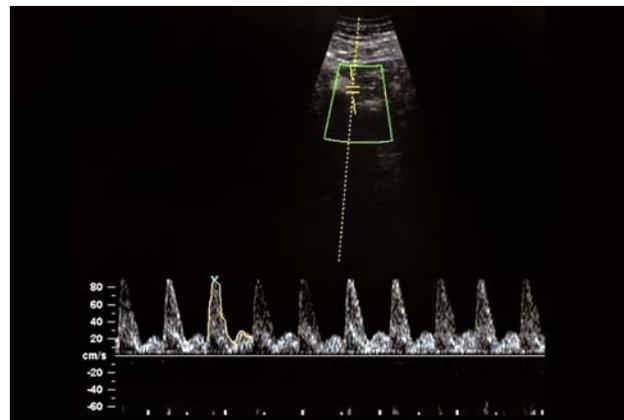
IUGR uterine artery spectral Doppler with increased pulsatility index and notching
